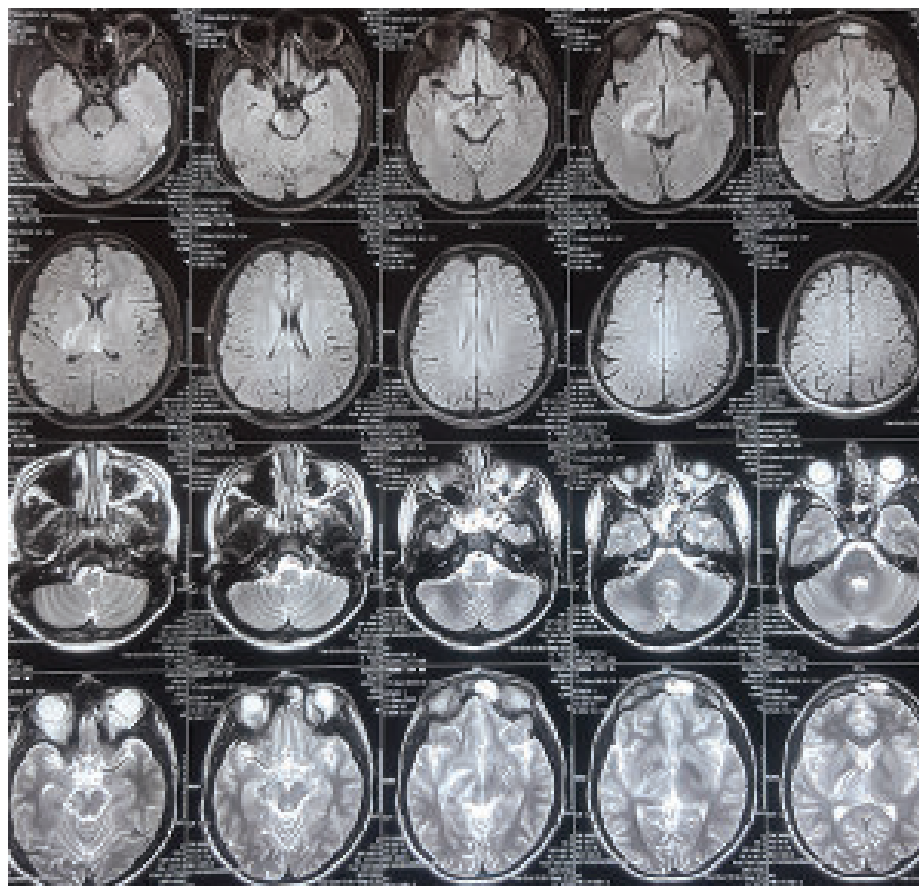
Multiaxial T2 and FLAIR sequence MRI of brain showing mixed intensity lesion in right thalamus, midbrain and part of capsuloganglionic area which showed blooming on GRE suggestive of haemorrhagic infarct.
